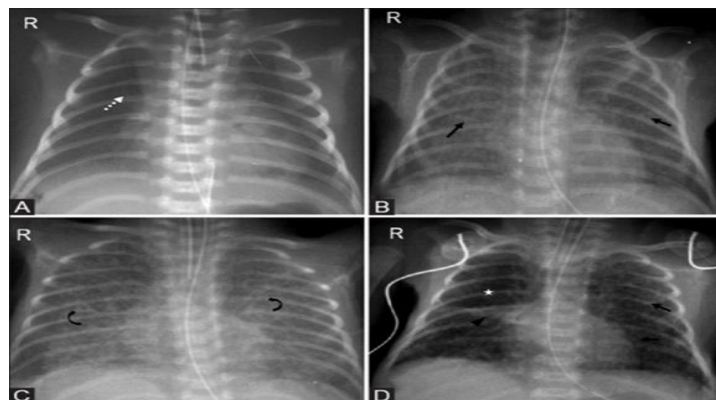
Radiographic transition from RDS to BPD ⁽⁵⁾
